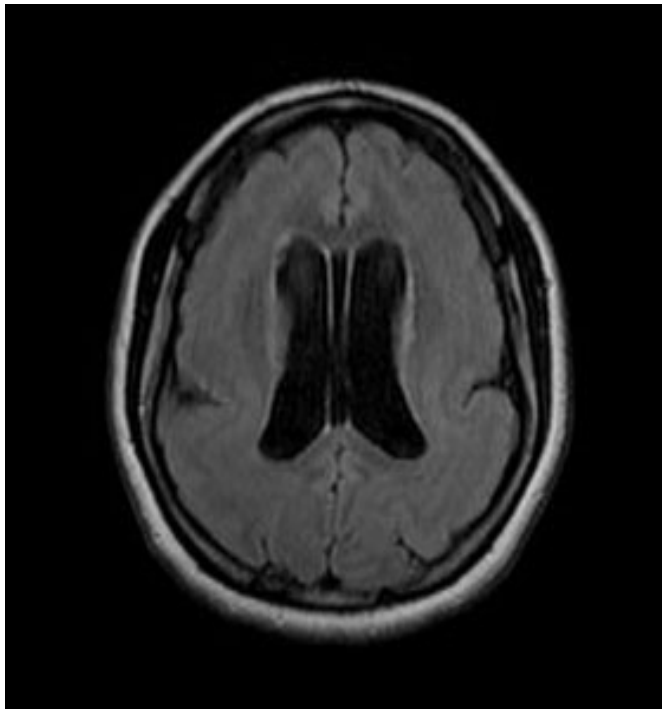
Axial T2 FLAIR revealed a complete band of gray matter located deep to, and roughly paralleling, pachygyric overlying the cortex.
